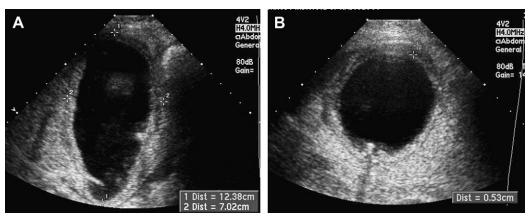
Acute cholecystitis with gallbladder enlargement. (A) Longitudinal view shows an enlarged gallbladder measuring 12.3×7.0 cm. (B) Transverse view shows a thick wall measuring 5.3 mm and a small stone. (Data from Middleton W. General and vascular ultrasound: case review series. Philadelphia: Mosby; 2007. p. 47.)
